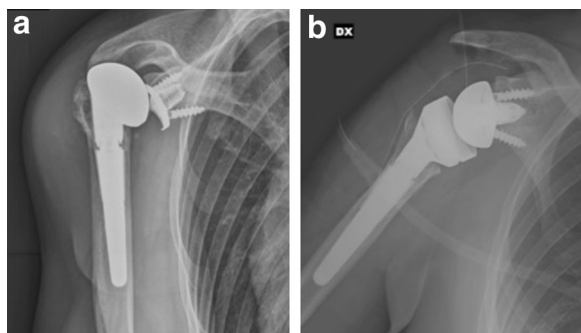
Rotator cuff failure in TSA. a Superior subluxation of the humeral head in TSA due to rotator cuff failure 6 years after surgery. b Post-operative X-ray after revision surgery with RSA facilitated by the use of a primary anatomic implant with a completely convertible system
